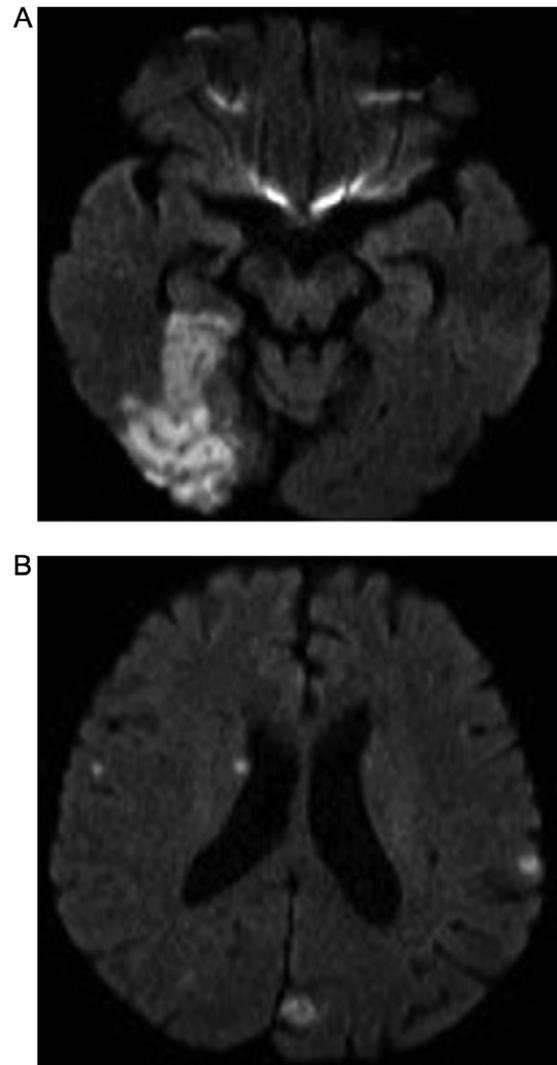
Same patient as Fig 6. Axial DWI shows multiple areas of restricted diffusion including a right occipital posterior cerebral artery territory infarct with possible associated cerebritis (A) and multiple small infarcts within the bilateral cerebral hemispheres (B).
